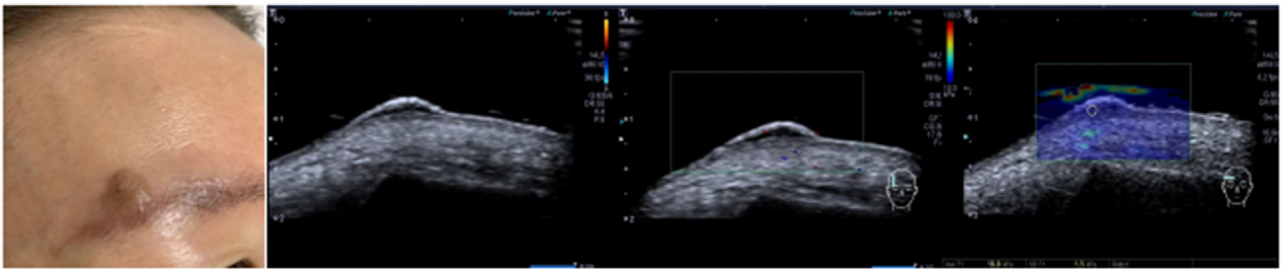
2D, Doppler, and SWE images of seborrheic keratosis
